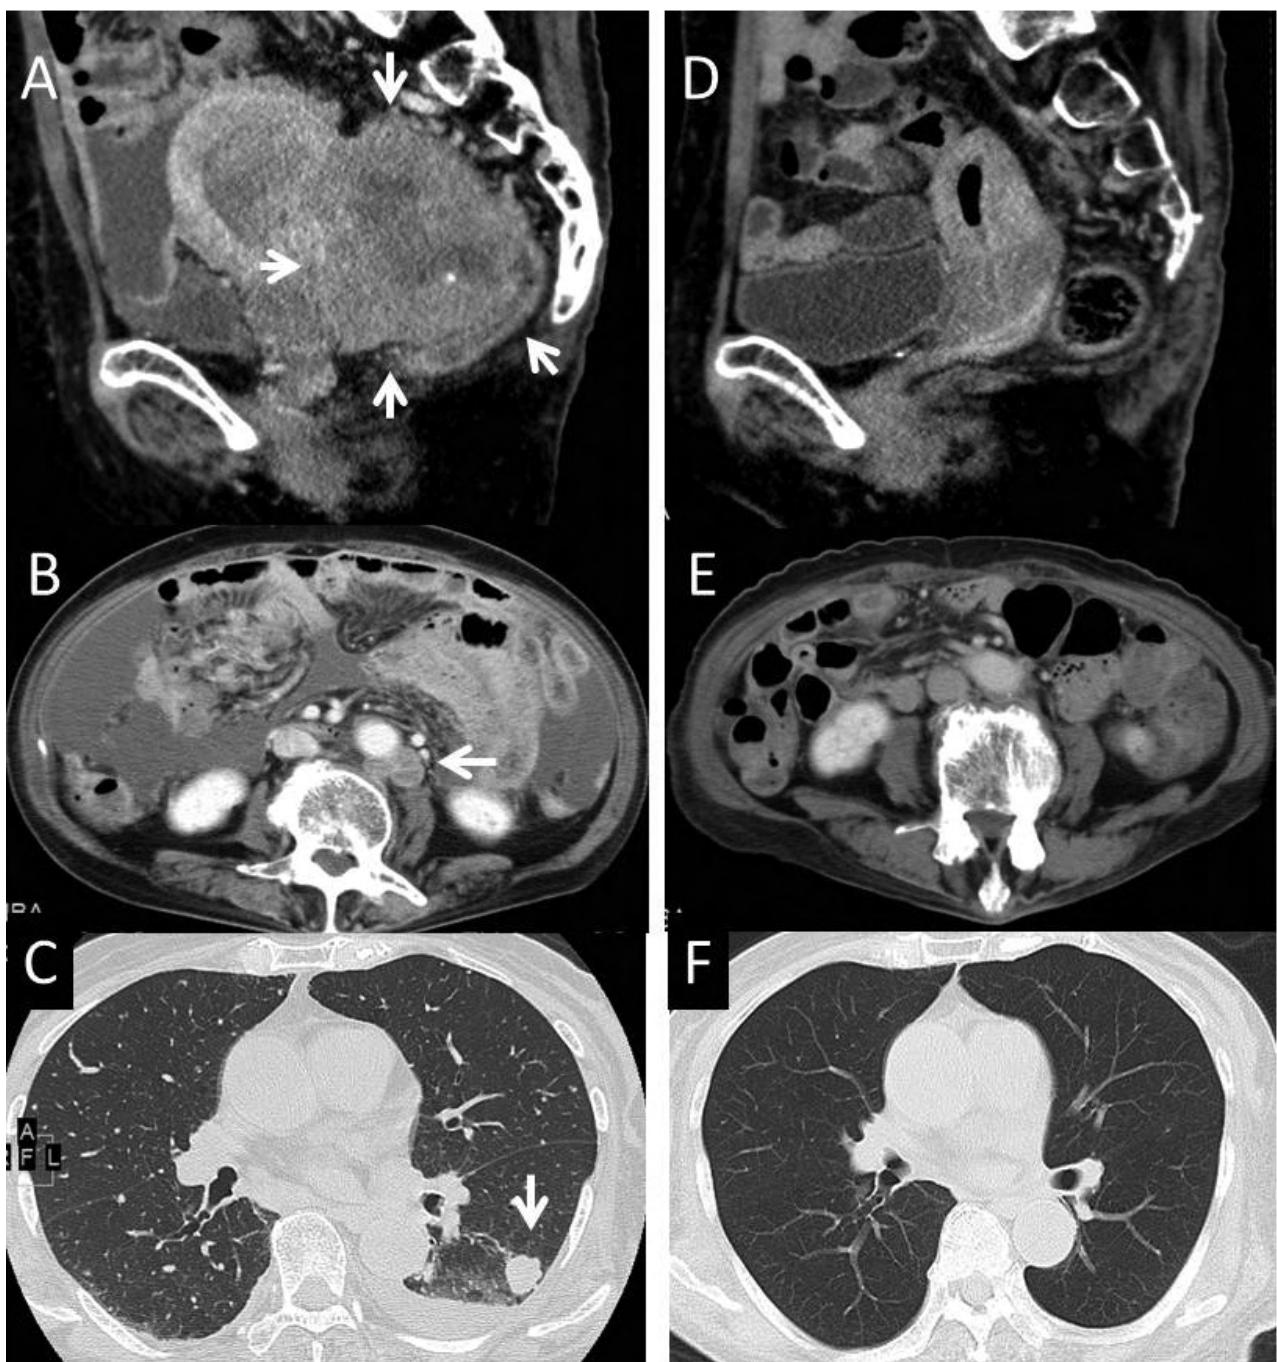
CT images of recurrent and refractory ovarian cancers. A, B, and C: recurrent and refractory tumors before combination therapy with bevacizumab and GEMOX (arrow). D, E, and F: all refractory tumors, massive ascites, and pleural effusion were not detected by CT images after four cycles of the therapy, achieving CR. Images D, E, and F correspond with images A, B, and C, respectively.
